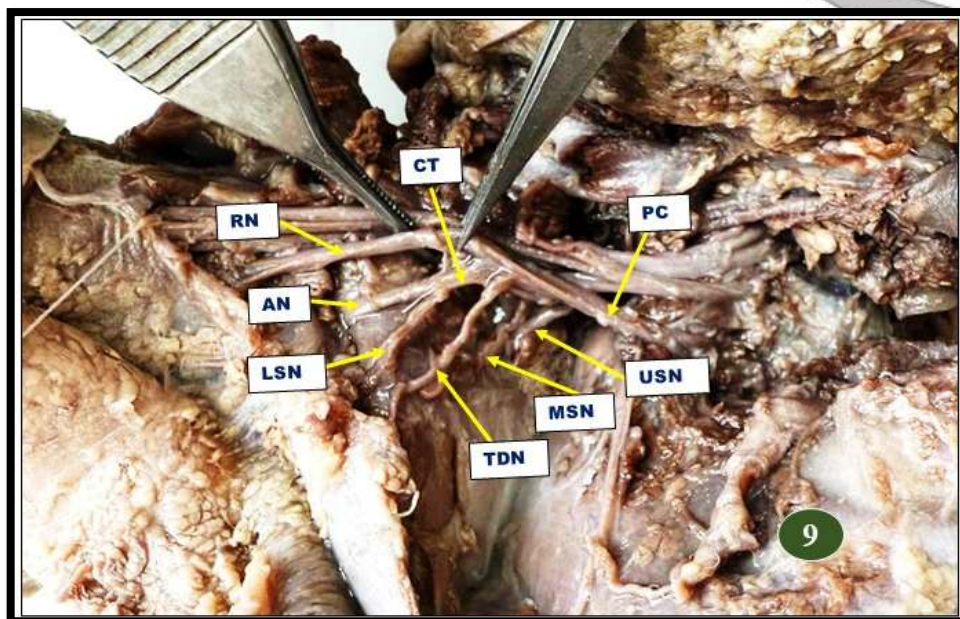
Common trunk (CT) for Axillary nerve and Lower subscapular Nerve from posterior cord of brachial plexus with 3 Subscapular nerves (USN, MSN, LSN)
